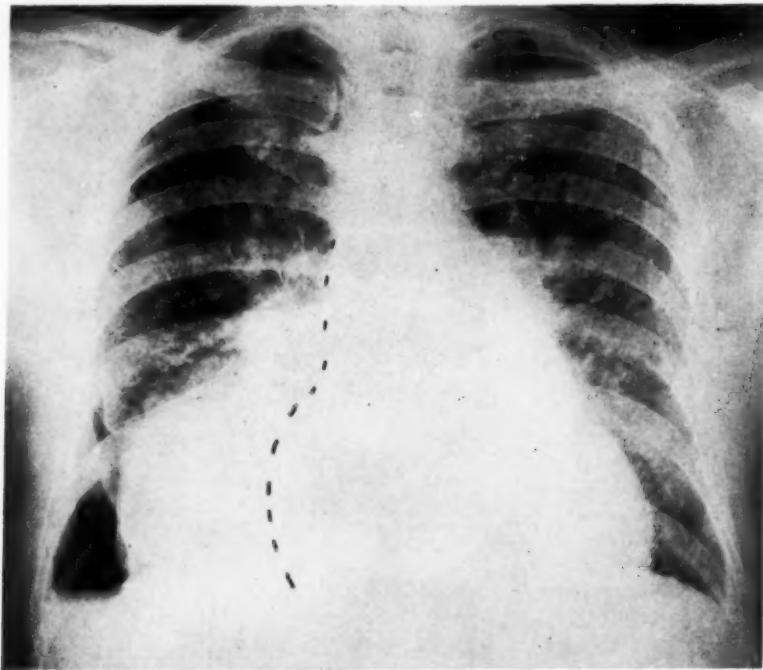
Roentgenogram of chest showing right hydropneumothorax, hilar vascular markings, and generalized cardiac enlargement with a prominent right cardiac border and the straight convex left cardiac border.
